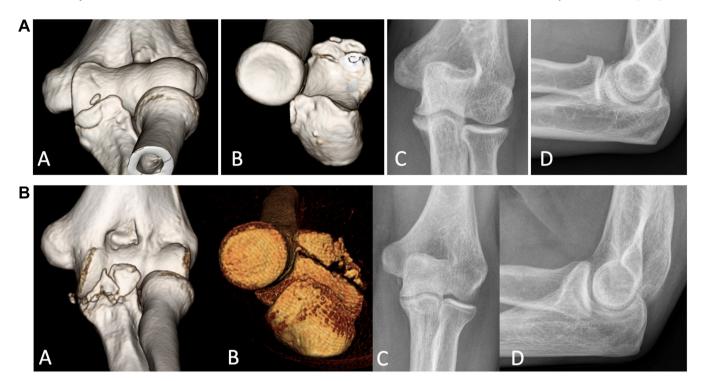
(A). A, B CT scan showing an example of an isolated coronoid fracture involving the anteromedial facet which doesn't have medial obliquity. This fracture was successfully treated nonoperatively and 9 months postinjury radiographs (*C*, D) demonstrating no evidence of incongruency, subluxation or joint degeneration. (B). A, B CT scan showing another example of a comminuted coronoid fracture involving the anteromedial facet with medial obliquity but no concavity of the main anteromedial fragment. This fracture was again successfully treated nonoperatively with 20 months postinjury radiographs (*C*, D) demonstrate no incongruency, subluxation or joint degeneration. *CT*, computed tomography.
